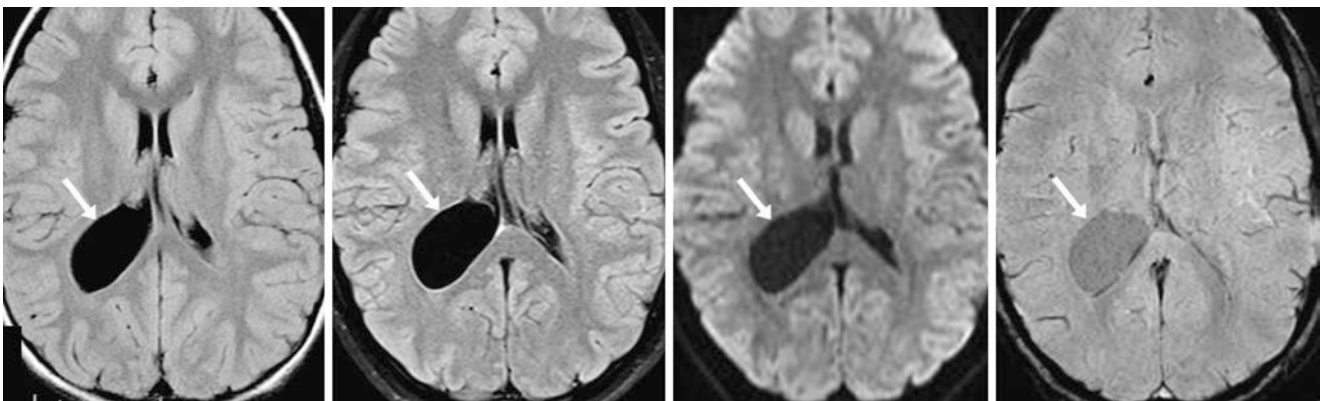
Comparison case of a large intraventricular cyst. An 8 year old with headaches had an enlarged right lateral ventricle on FLAIR (left) caused by a 4.0-cm cyst (arrows); there was no hydrocephalus or parenchymal lesion. At 21 years of age (13 years later), with worsening headaches, FLAIR (left middle), DWI (right middle), and SWI (right
